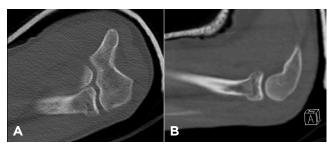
A) Coronal and B) sagittal computed tomography scan slices of the left elbow, post-reduction, showing improved alignment of the radial neck fracture and elbow joint line congruence.
